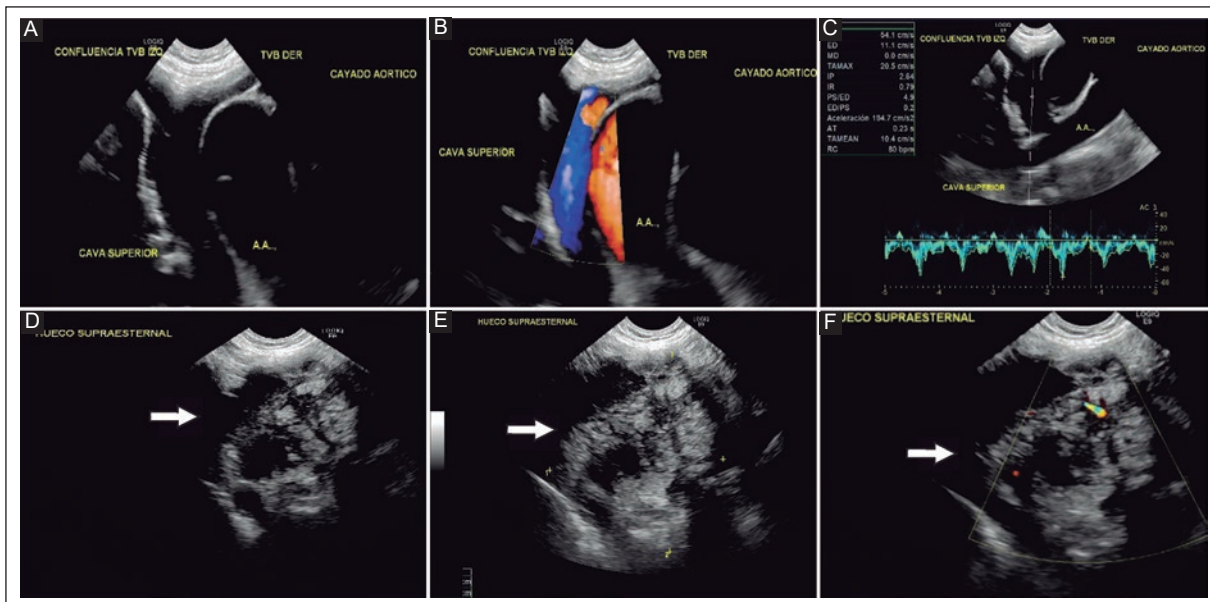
Normal US duplex Doppler in a 36-year-old female patient with a normal diameter (A), patency (B), and flow velocity (C) of the superior vena cava with a suprasternal approach. Abnormal Doppler US in a 42-year-old male patient with a solid mass (lymphoma) (D) (arrow) of 6.4 cm x 5.9 cm (E) (arrow) with intralesional vascularity in the mediastinum (F) (arrow) that did not allow identification of the superior vena cava.
